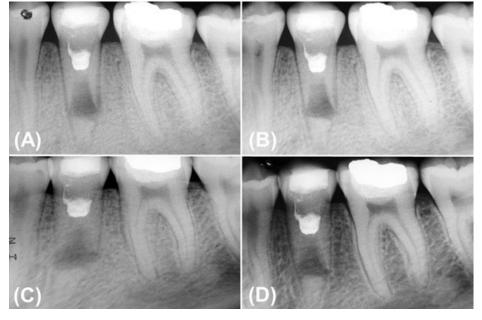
A. Radiographic image with alveolar cortical bone formation and maintenance of tooth in function, after 1 month. B. After 6 months C. After 12 months. D. After 2-year follow-up.
